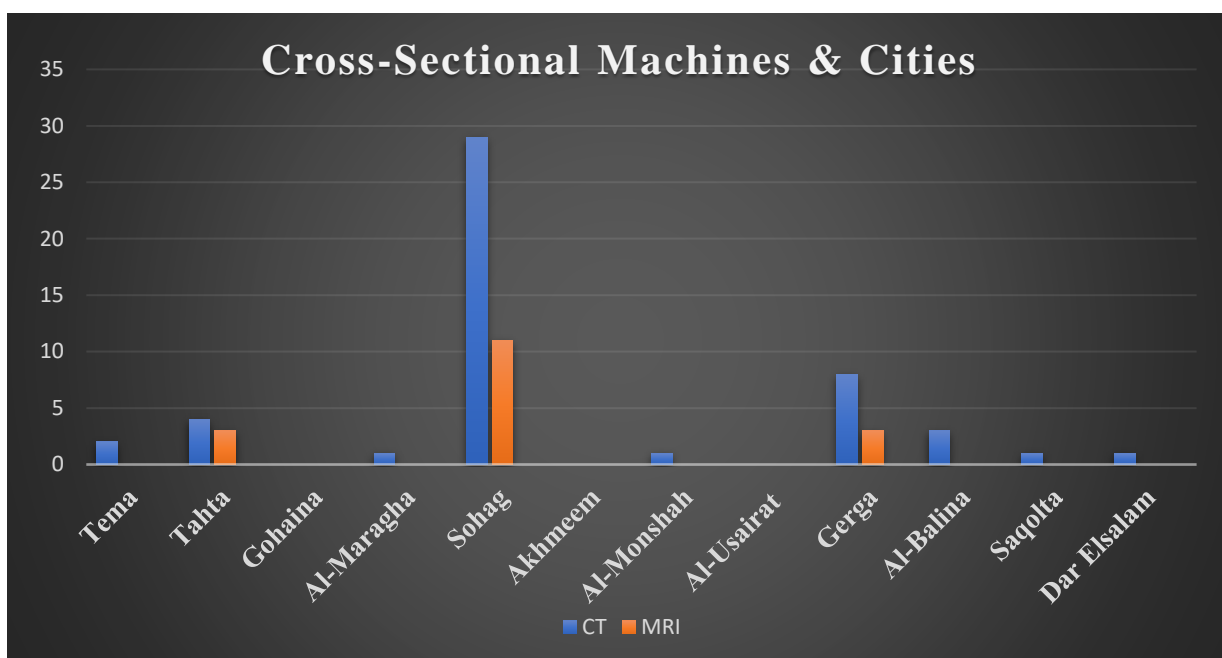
Numbers of CT and MRI machines in different cities in Sohag governorate.
